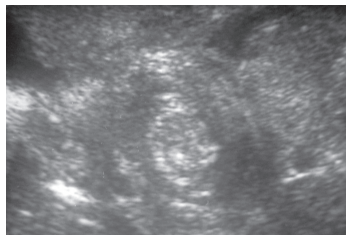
Ultrasound showing target sign
